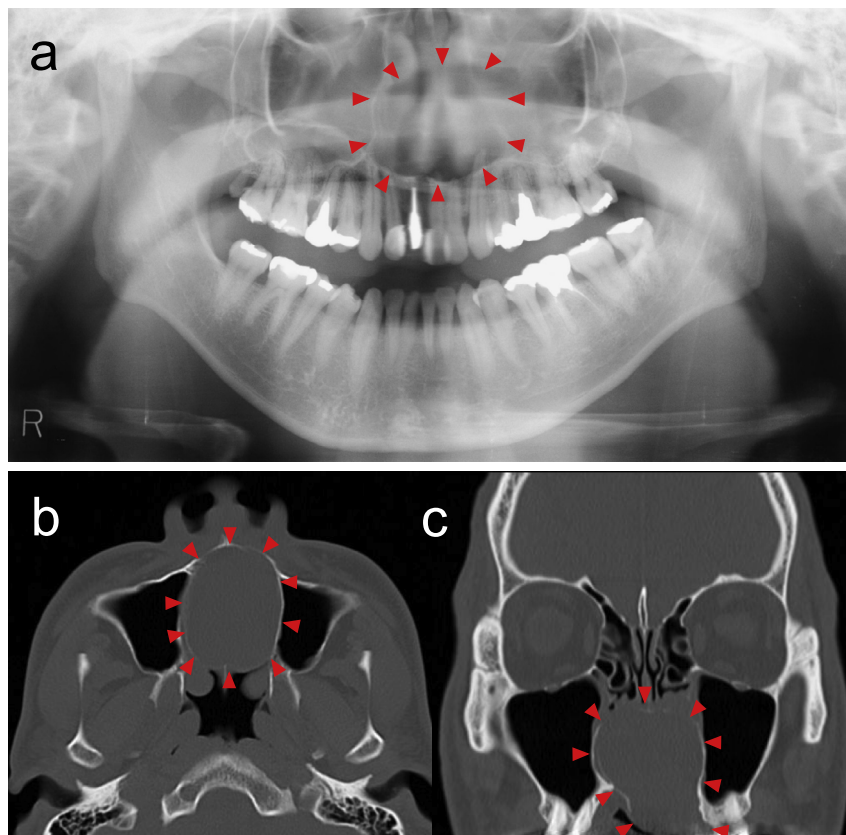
Preoperative panoramic radiograph and computed tomography (CT). Panoramic radiograph (a), axial (b), and coronal (c) views demonstrating the radio-transparency at the upper maxillary midline.
